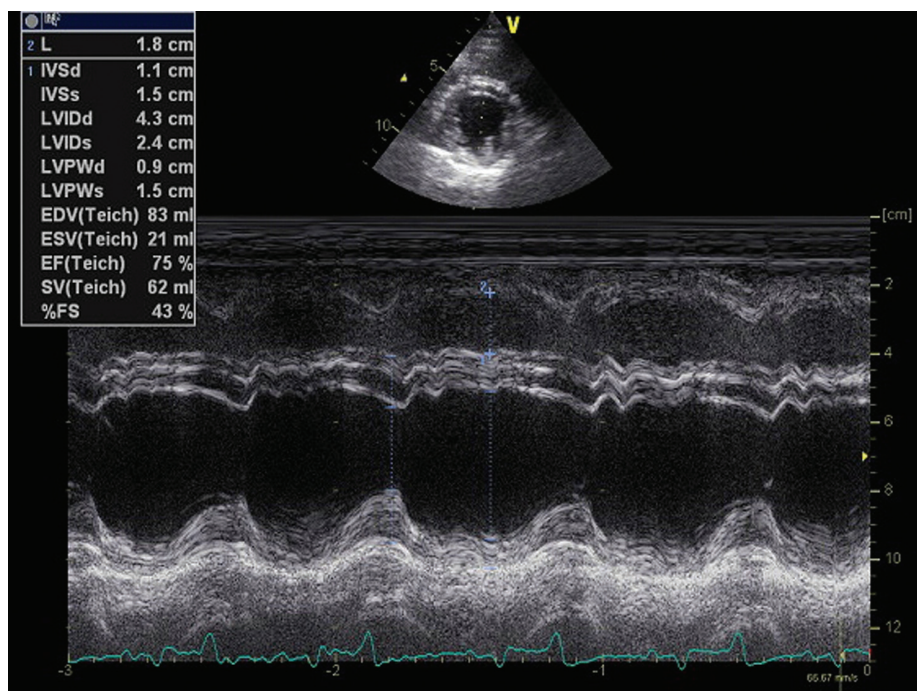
Time-motion mode right parasternal short-axis view of the left ventricle at the chordal level used to measure the right ventricular internal diameter (2), the interventricular septal and left ventricular free wall thicknesses (IVS and LVPW, respectively) and the left ventricular internal diameter (LVID)
